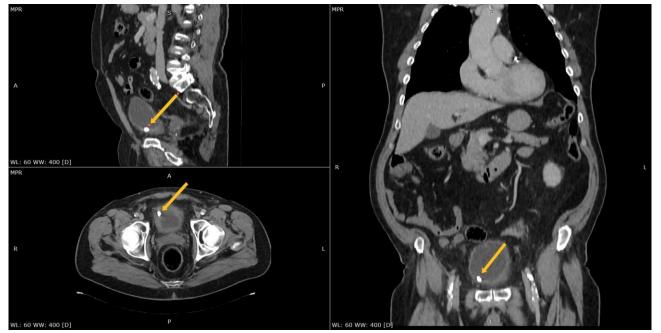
BioXmark[®] in a bladder, 9 months follow up CT scan.
